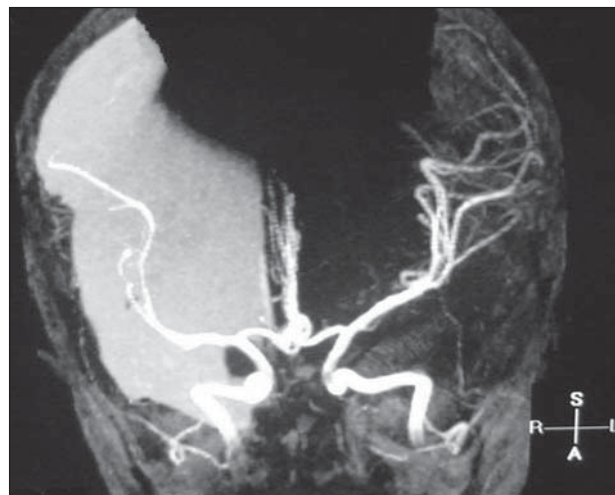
MRI angiography showing no vascular abnormality.
